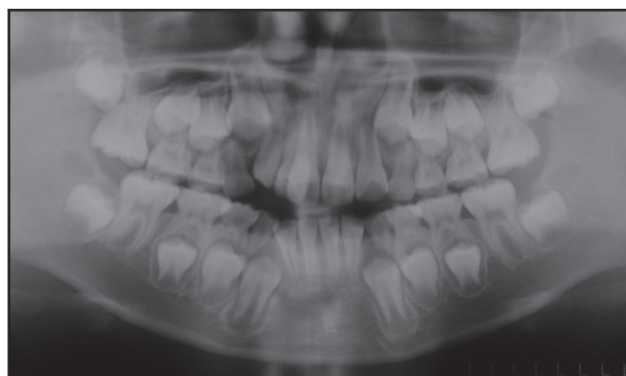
Case 3: A panoramic radiograph, taken at the age of 8 years, 1 month, shows that the 2 maxillary lateral incisors on the right side are erupting.
